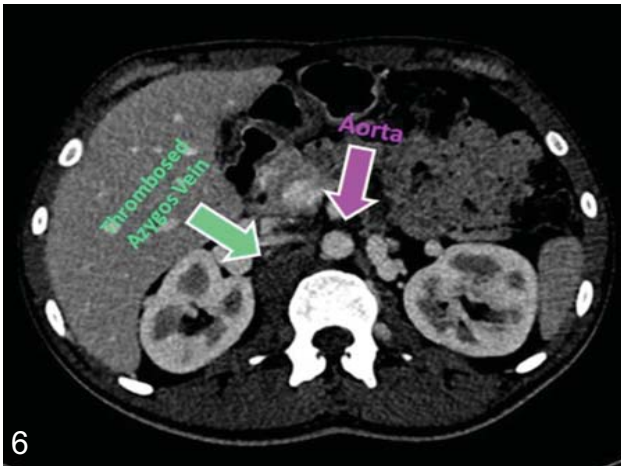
5&6: CT scan with contrast axial images showing severe stenosis of intrahepatic IVC, extensive collaterals and thrombosed azygos vein.
